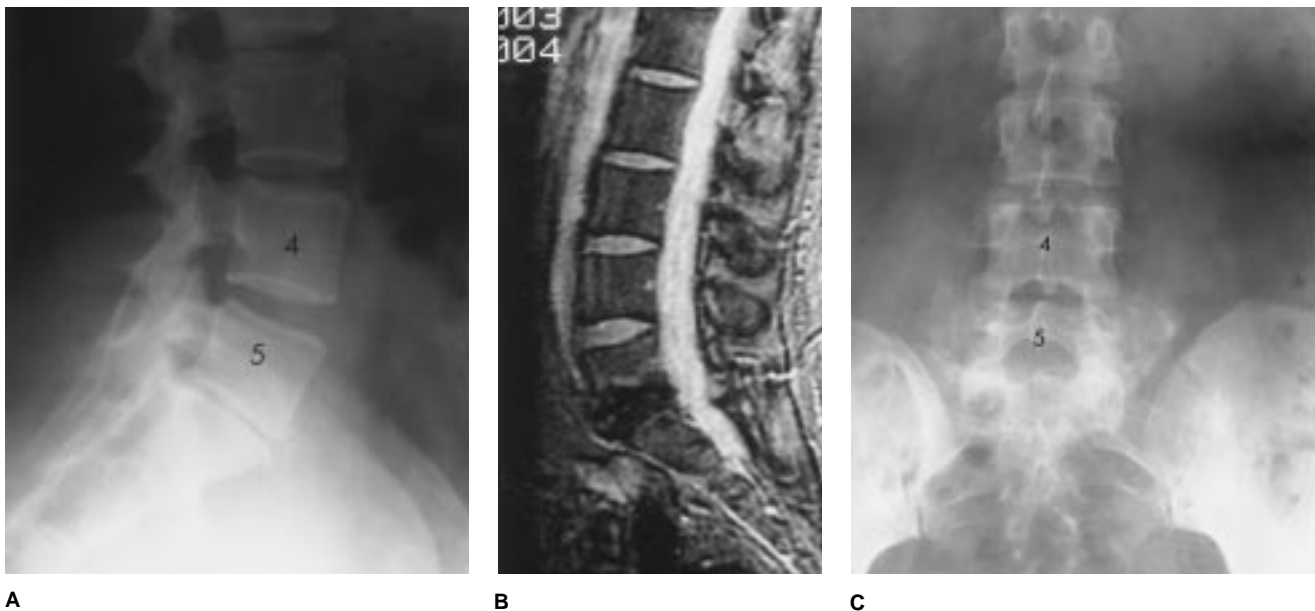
Images of a patient with disk degeneration. A, Lateral lumbar radiograph depicts the loss of disk height at the L5-S1 interspace. B, Sagittal MR image depicts a "black disk" at L5-S1. C, Postoperative AP lumbar radiograph shows a solid arthrodesis at L5-S1.
